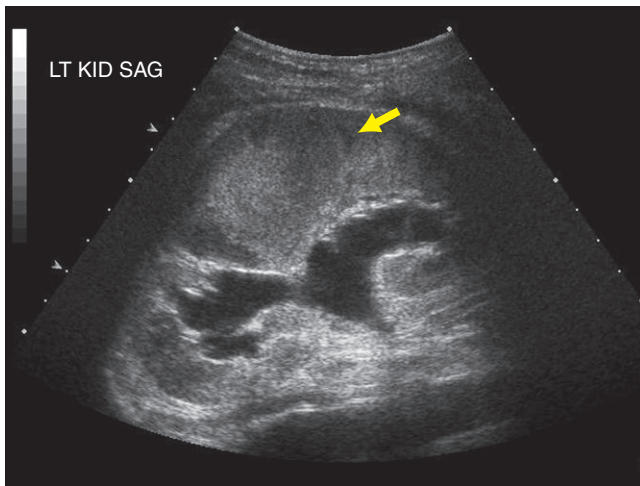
Ultrasound of the left kidney demonstrates hydronephrosis and hypoechoic mass involving the mid portion of the left kidney (arrow).
